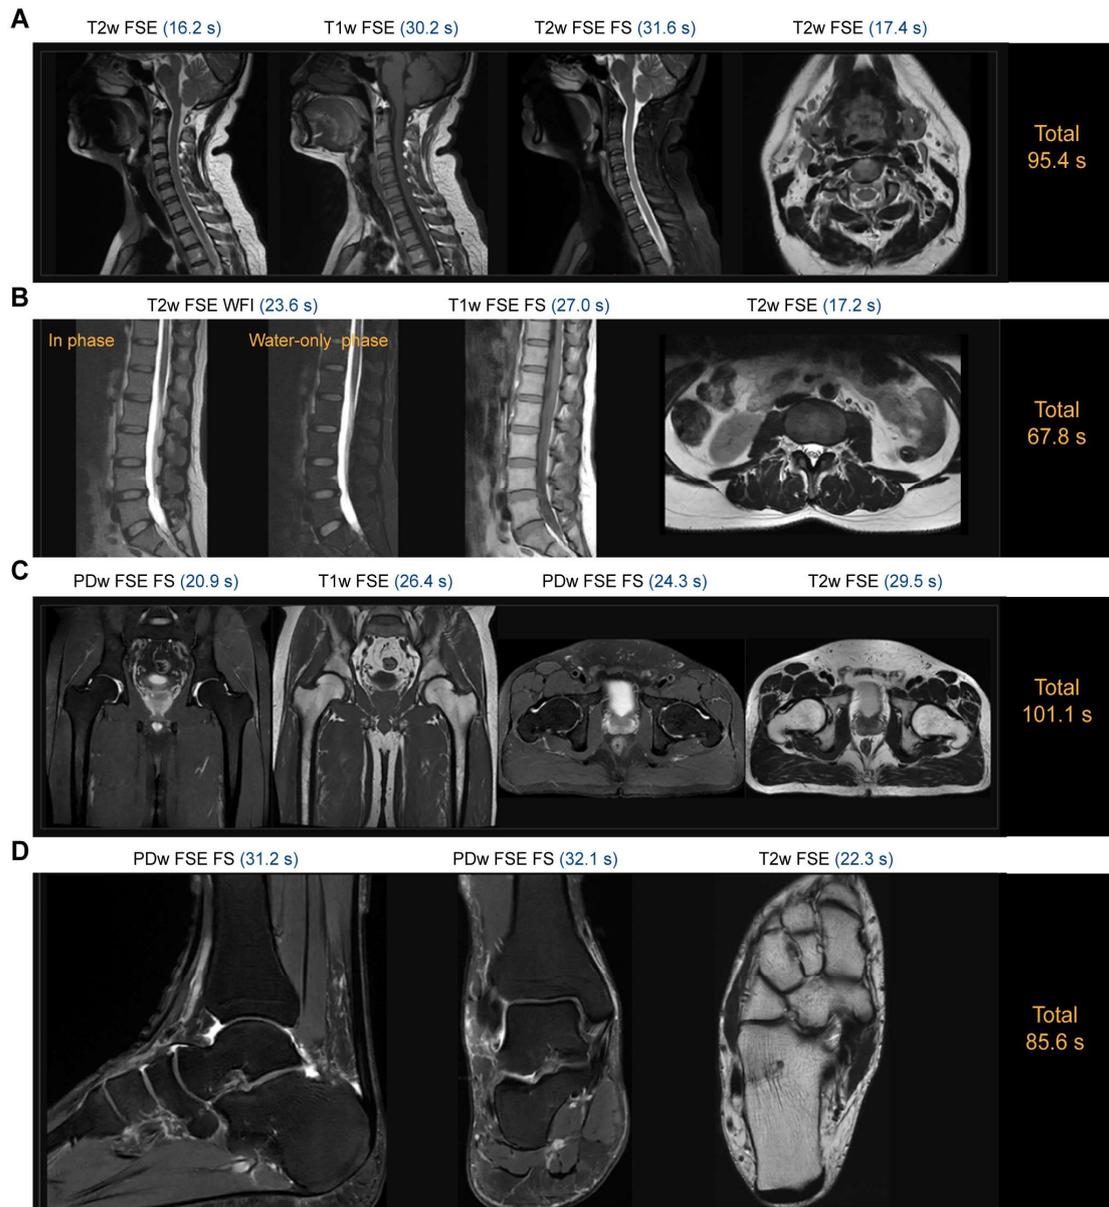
ACS reconstruction of 100-s level fast MRI scans for multiple organs. Related to Figure 4. ACS achieves 100 s-level fast MRI scans for cervical spine (A), lumbar spine (B), hip joint (C), and ankle joint (D). Reasonable reconstruction can be achieved for 3 to 4 fast MRI scans performed in ~100 s using different pulse sequences.
